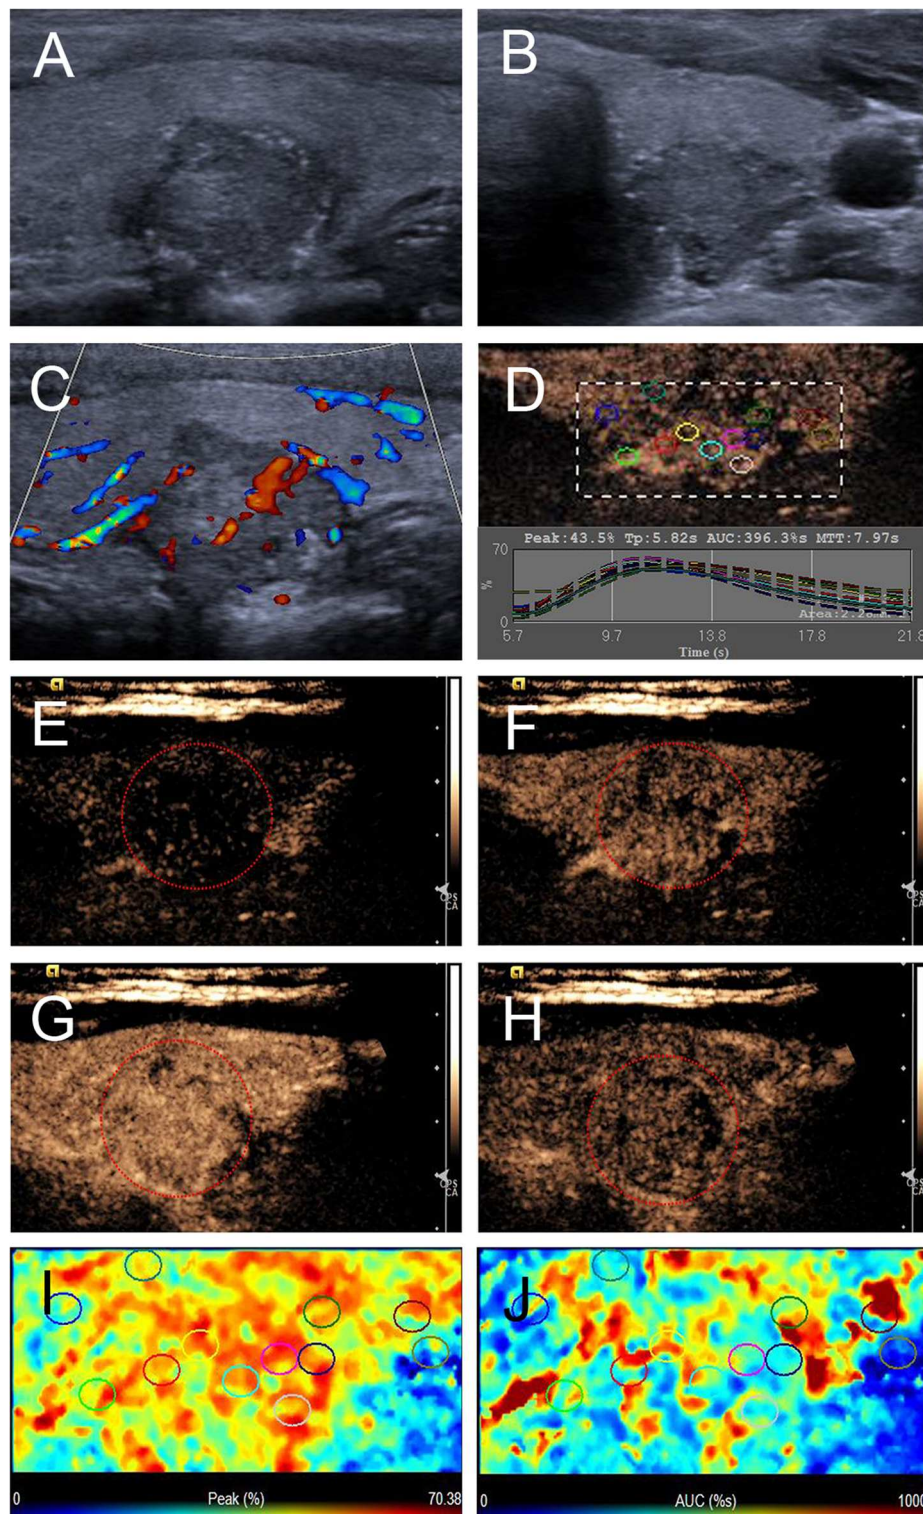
Ultrasound images of a 26-y-old female PTC patient with petal-like calcification of the left thyroid lobe. (A) Longitudinal and (B) horizontal gray-scale sonograms; the thyroid nodule had a solid component, hypoechoic echogenicity, ill-defined margin, and capsule contact with protrusion. (C) Color Doppler sonogram showed moderate internal and peripheral vascularity. (D) TICs of the thyroid nodule and peripheral thyroid parenchyma with different regions of interest (different color circles). (E–H) CEUS sonograms of the thyroid nodule (E) at 6 s (wash-in), (F) 9 s (wash-in), (G) 11 s (time to peak), and (H) 15 s (wash-out), revealing diffuse, and heterogeneous enhancement (circle) across the whole lesion. (I) Parametric color map showing that peak intensity values for the nodule were mixed with red and yellow, and adjacent thyroid parenchyma were blue and yellow, indicating that the peak intensity of the nodule was higher than that of the peripheral thyroid parenchyma. (J) Parametric color map showing that AUC values for the nodule were mixed with blue, yellow and red, and adjacent thyroid parenchyma were almost the same, indicating that the AUC of the nodule was equal to that of the peripheral thyroid parenchyma.
